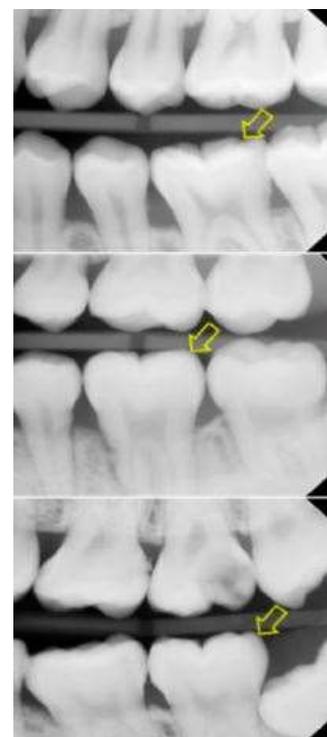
Taking an image of Bitewing bite radiography (left) and sample images (right).
